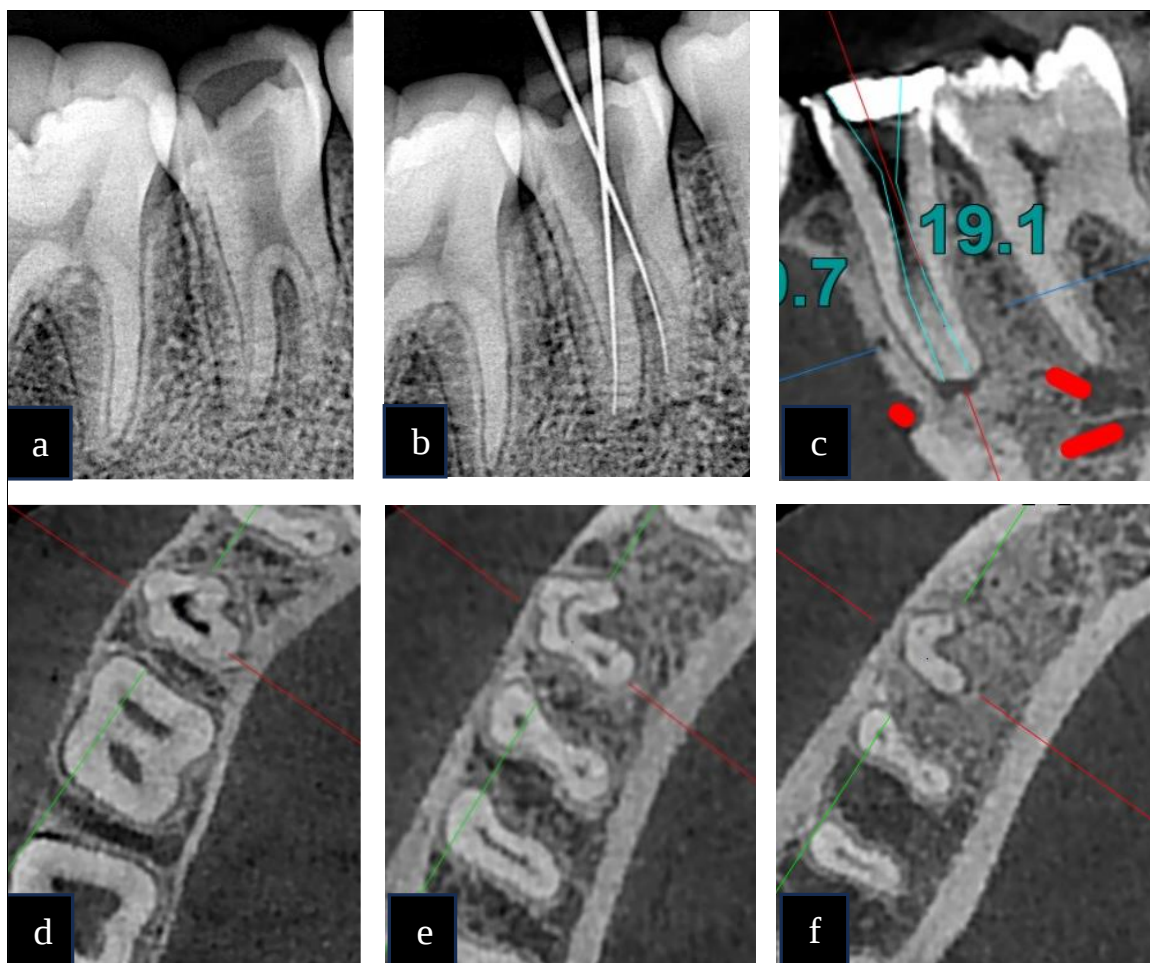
(a) Preoperative radiograph. (b) Exploration of canals prior to CBCT. (c) Sagittal view CBCT showing MB, DB canals with elongated pulp chamber. (d) Axial view CBCT at cervical one third of root showing all canals fused. (e) Axial view CBCT at middle one third of root showing MB, DB canals fused and separate DL canal. (f) Axial view CBCT at apical one third of root showing three exiting points.
